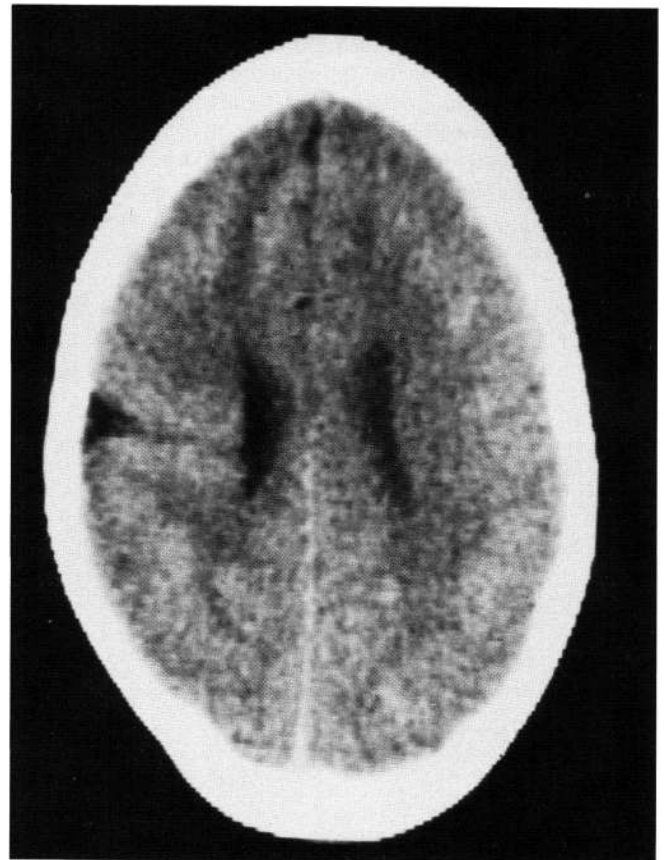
Schizencephaly in a 13-year old mentally defective male. Contrast enhanced CT-section shows full-thickness cerebral cleft on one side (other side similarly affected, not shown at this level), bordered by heterotopic grey matter.
